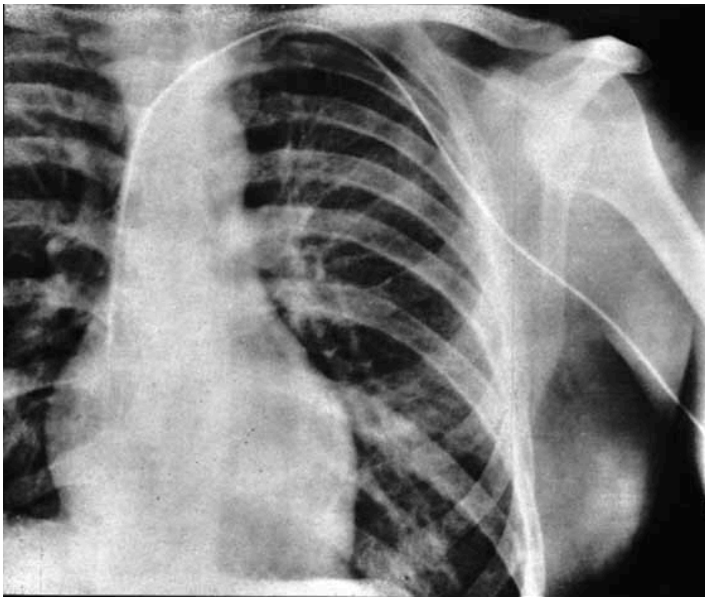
The Chest X-Ray of Dr Werner Forssman showing the catheter advanced from the left ante-cubital vein and lying with the tip within the right atrium.
